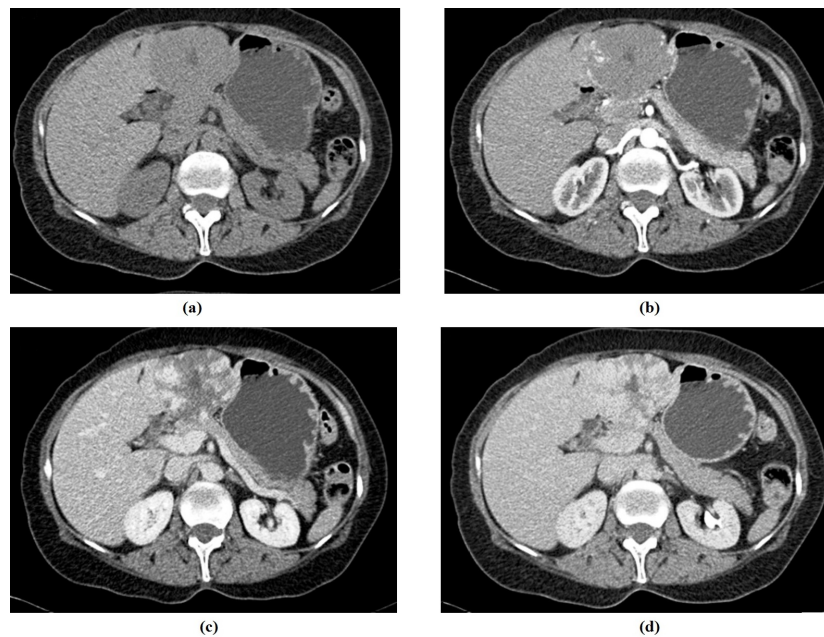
Example of CT scan image in four phases. (a) CT image before contrast injection. (b) arterial phase. (c) portal phase. (d) delay phase
